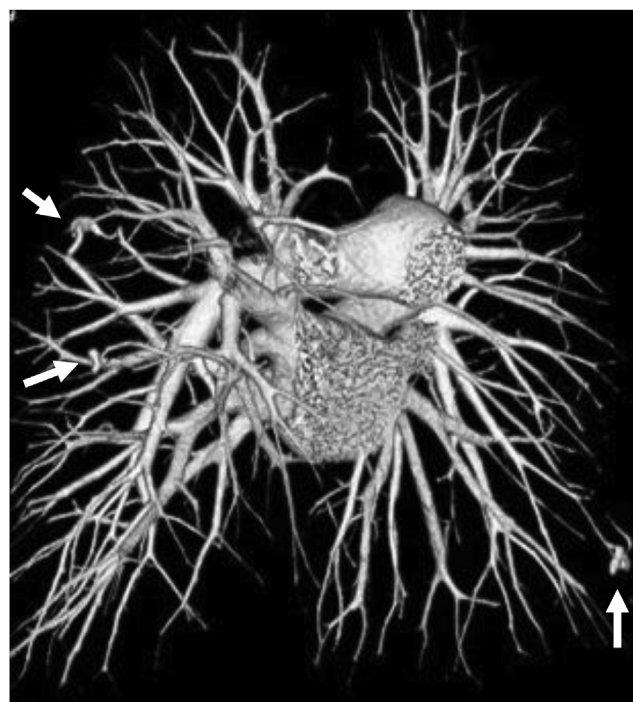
Case 2. 3D-CT angiography reveals PAVMs (arrows) located in right middle and lower lobe, and left upper lobe. They are located in right S4, S6, and left S4. The sizes of them are 5 mm, 7 mm and 5 mm in diameter, respectively. They are simple type and supplied by a feeding artery of 3–4 mm in diameter.
